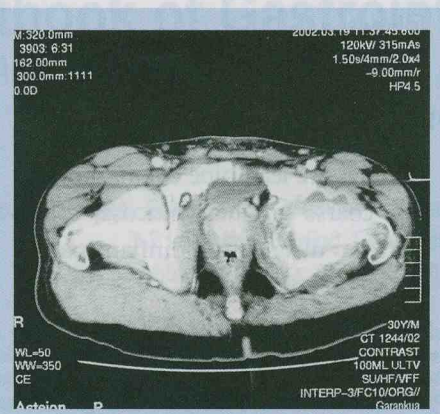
CT scan of the hip showing extent of bone destruction and soft-tissue involvement.
